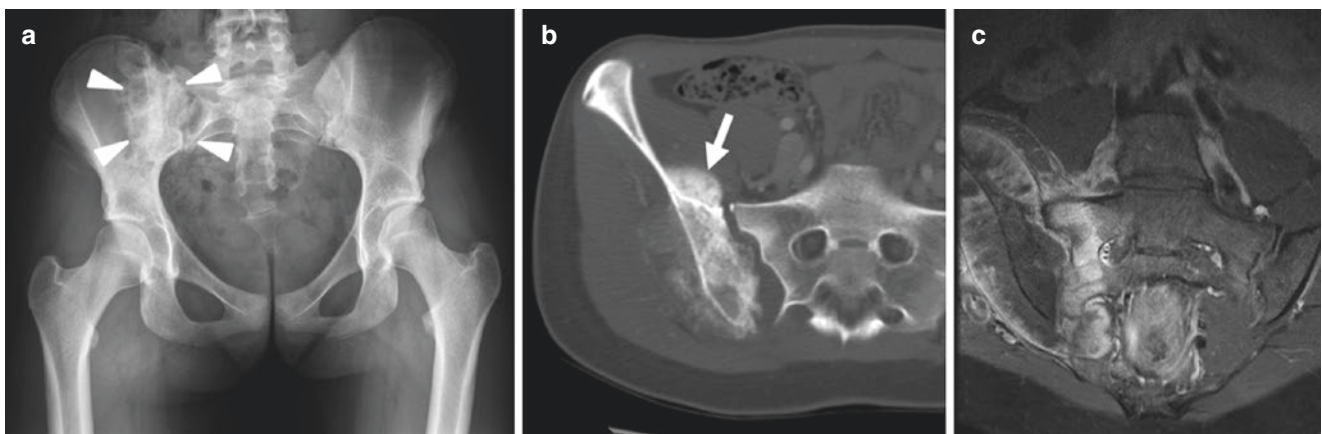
A frontal radiograph (a) in a 16-year-old with low back pain demonstrates a large sclerotic lesion projecting over the sacroiliac joint (a—arrowheads). An axial CT image shows a large associated soft tissue mass with cloudy-like areas of matrix mineralization
